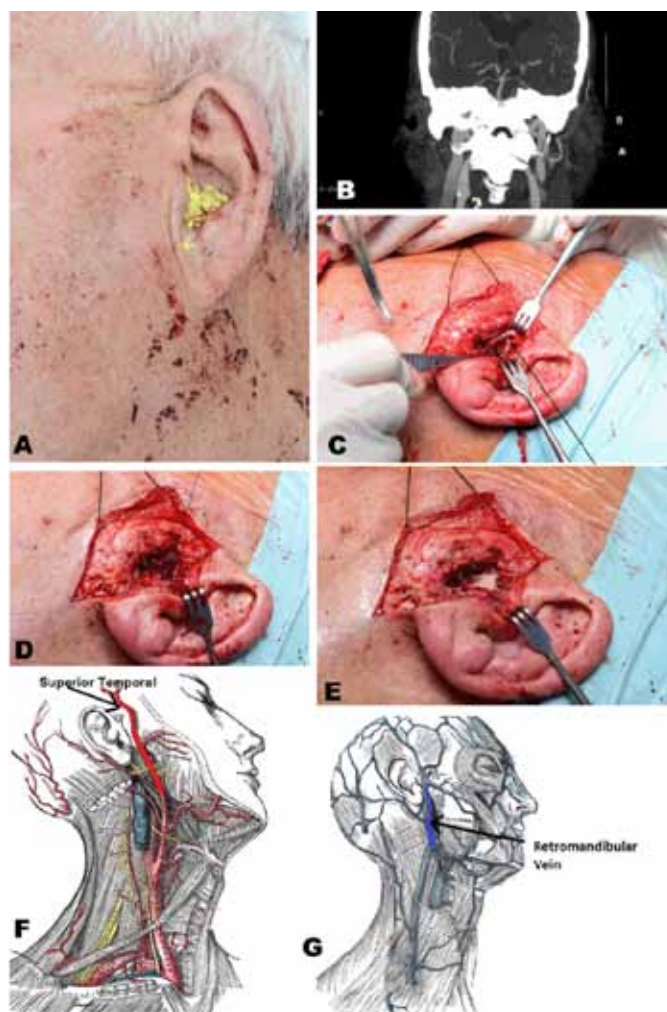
(A) Bismuth Iodoform Paraffin Paste dressing, (B) Coronal view of computed tomography scan showing loss of contrast between points A + B, where pseudoaneurysm has formed, (C) Partially tied off pseudoaneurysm of superficial temporal artery, (D) Tied off Pseudoaneurysm of superior temporal artery, (E) Excised pseudoaneurysm of superior temporal artery, (F) Superior temporal artery, and (G) Retromandibular vein.
